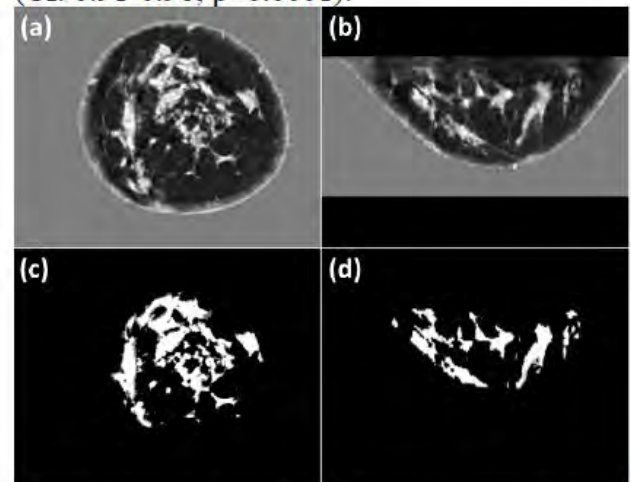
(a) Coronal and (b) axial speed-of-sound images generated by transmission ultrasound; (c) and (d) show the segmented fibroglandular tissue (with the skin), respectively.
